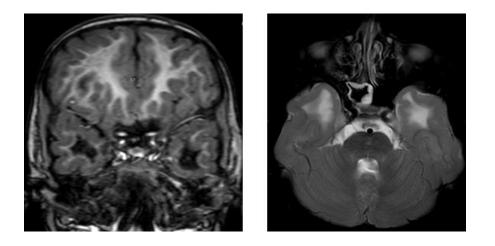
Rash, Coarctation and Salt-pepper retinopathy; MRI shows Temporal lobe vacuolation cyst. CT (not shown here) shows basal ganglia and left parito-fronto-occipital calcifications – CMV infection
